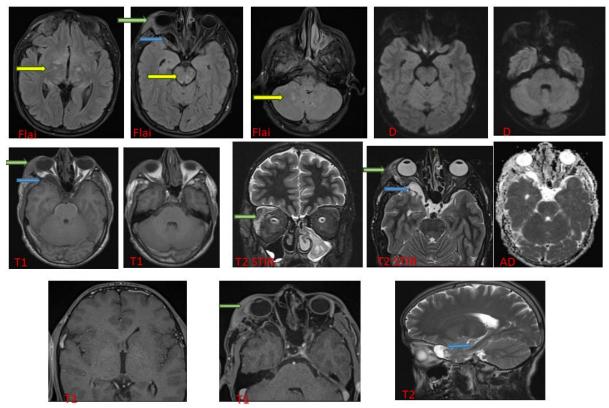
MRI images showing the sphenoid agenesis with dilation of the subarachnoid spaces (blue arrow) associated with a nodular lesion of the external canthus of the right eye corresponding to a neurofobroma (green arrow), these lesions are responsible for a grade I exophthalmos, we have also objectified multiple signal abnormalities of basal ganglia and the white matter infra and supra-tentorial corresponding to FASI (yellow arrow)
